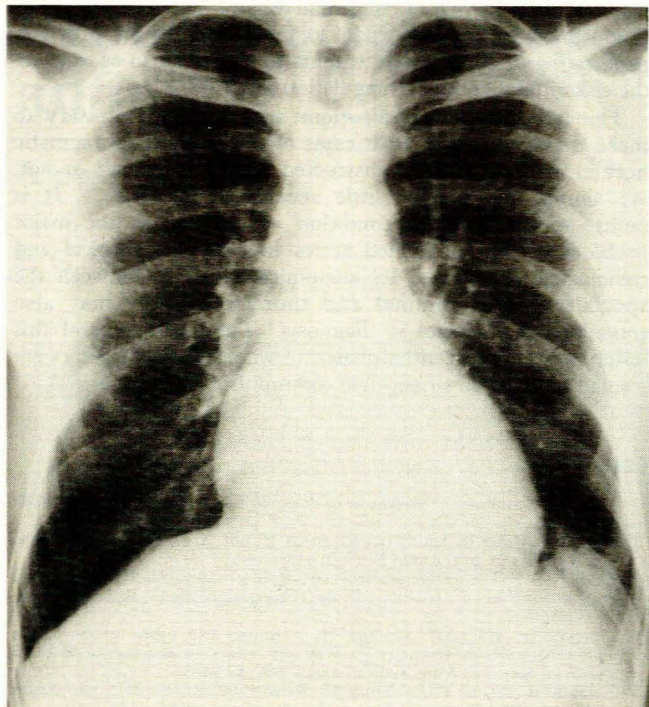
Case 5. Pre-radiography clinical diagnosis: pancreatitis or gastritis. The radiographs were reported to be consistent with the 'colon cut-off' sign of pancreatitis together with infection at the left base. Operation: obstructed viable colonic hernia. The patient survived. Top: small non-specific abnormality can be seen at the left base. Bottom: dilated transverse colon containing a little fluid.
